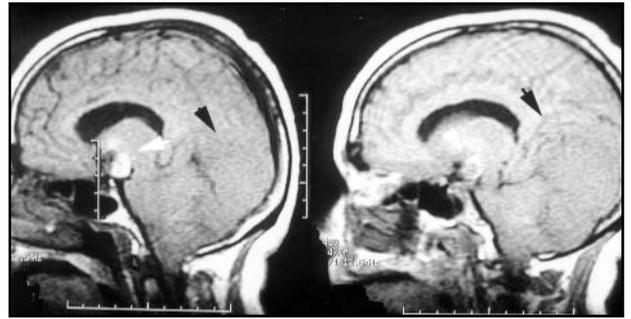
Magnetic resonance imaging demonstrating a tentorial meningioma extending to the occipito-temporal region and posterior fossa. Supratentorial aneurysm can be seen.
